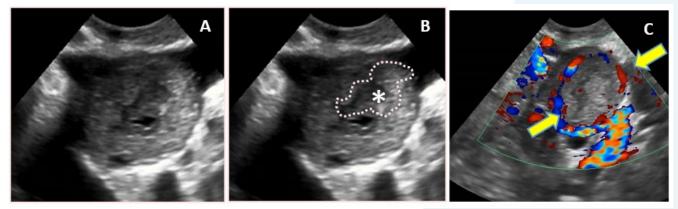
Ultrasound of right ovary. A. Gray scale. B. Same image as A. Dashed outline of renulated inner margin. Internal echoes present (asterisk). C. Demonstrates intense peripheral ring of fire (arrows).
